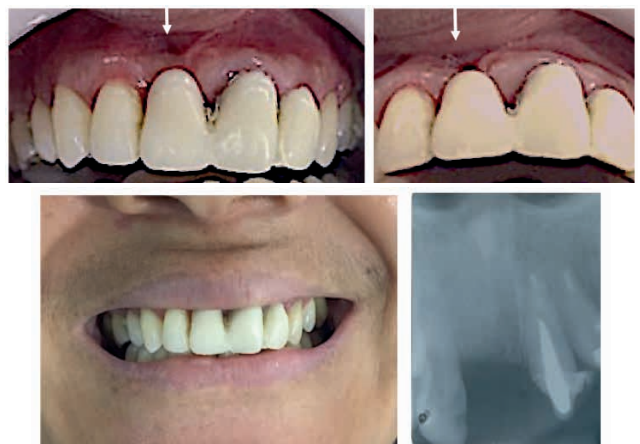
Preoperative clinical-radiographic view of the Seibert Class I alveolar ridge defect (arrow).
